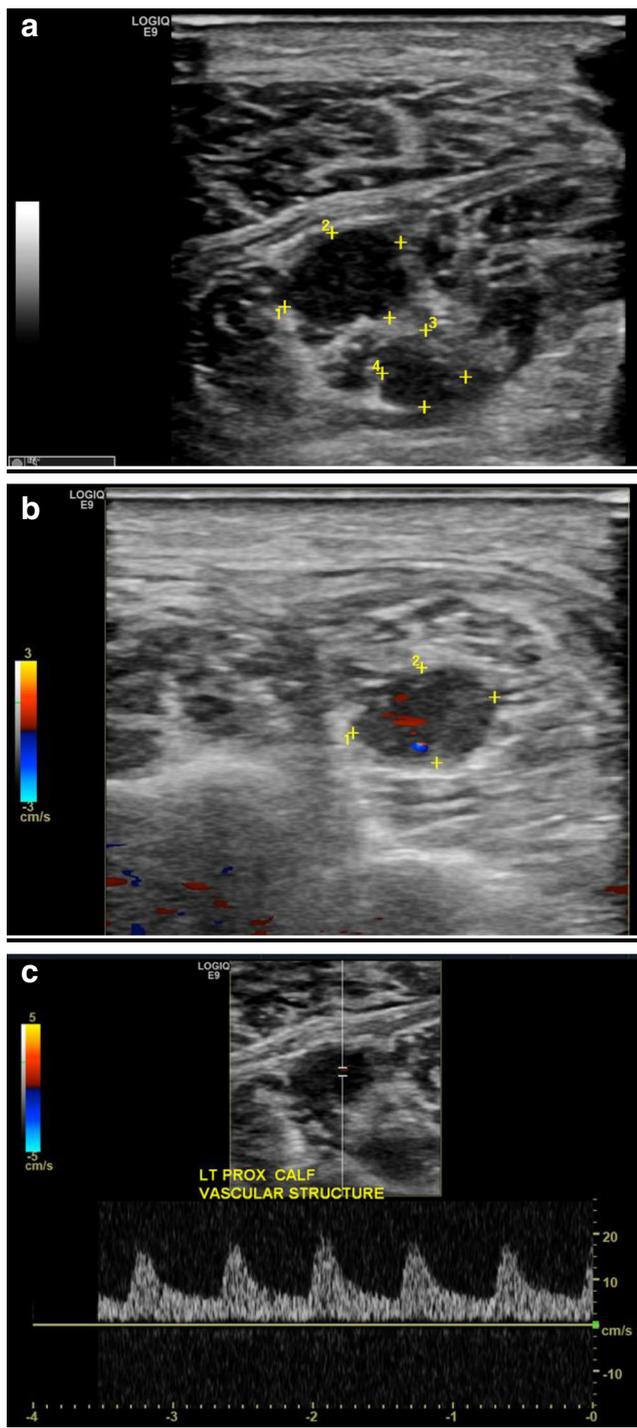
a Grayscale ultrasound image of the proximal calf shows heterogeneous hypoechoic foci within the deep posterior compartment musculature. b Power Doppler and c spectral Doppler ultrasound images show a vessel within the central portion of the lesion, but absent blood flow at the periphery, suggesting the perivascular nature of the foci
